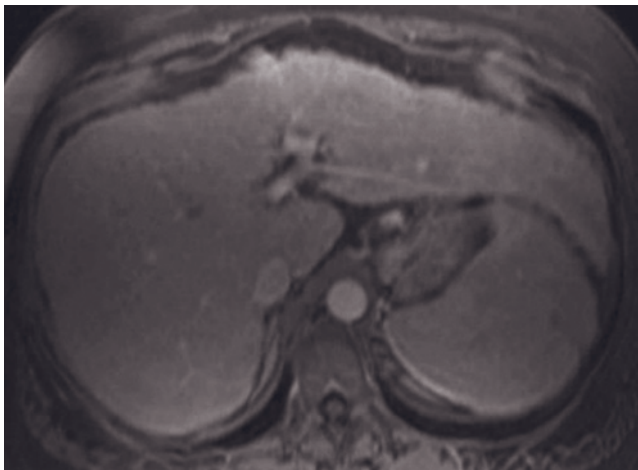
(Continued) T2-weighted fat-suppressed SS-ETSE (*j*, *k*), SGE (*g*, *h*), out-of-phase SGE (*b*, *m*), and immediate (*i*, *n*) and 90-s fat-suppressed (*j*, *o*) postgadolinium SGE images in a second and third patient with low-grade dysplastic nodules. In both cases, the low-grade dysplastic nodules are most evident on T1 (*g*, *h*) and out-of-phase (*b*, *m*) images. On the other sequences, the low-grade dysplastic nodules have signal intensity similar to background parenchyma.
